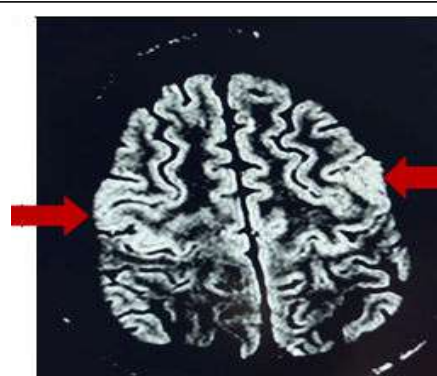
Axial flair sequence showing new areas of signal hyperintensity involving left motor cortex, with pre-existing changes in right pre-motor cortex MRI brain day 14.
